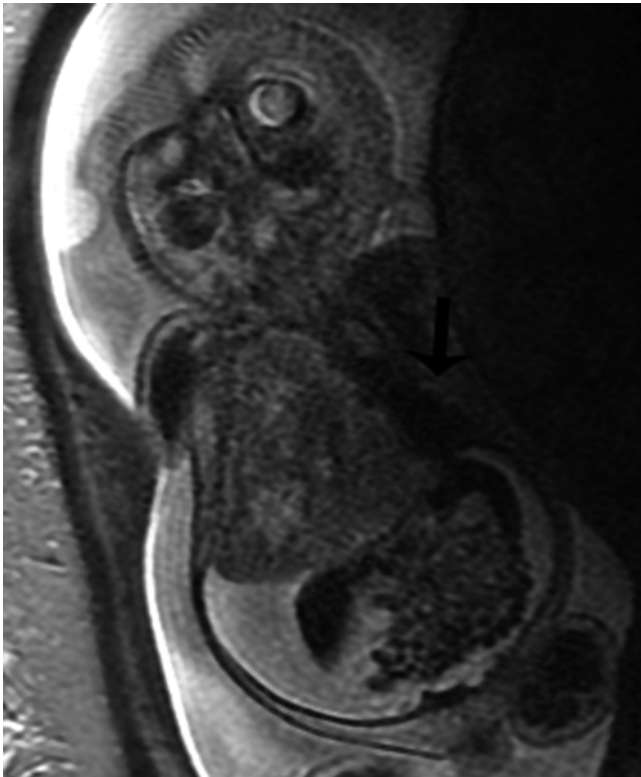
Type III CPAM with hydrops at 28 weeks gestation. Coronal SSFSE MR image demonstrates a large heterogeneous mass in the right thorax deviating the heart to the left (*arrow*). CVR was 5. There is diffuse skin edema and ascites. The fetus died despite steroid therapy
